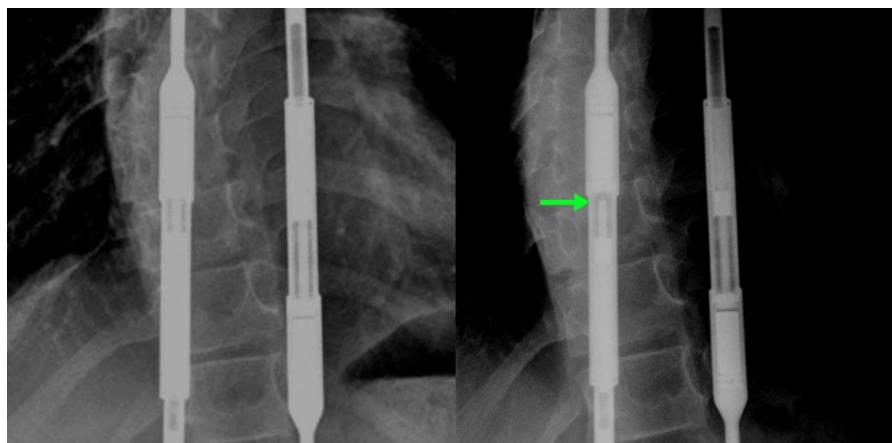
Anteroposterior radiographs demonstrating MAGEC rods of first patient (Left) before and (Right) after lengthening pin fracture (green arrow) within right rod.
